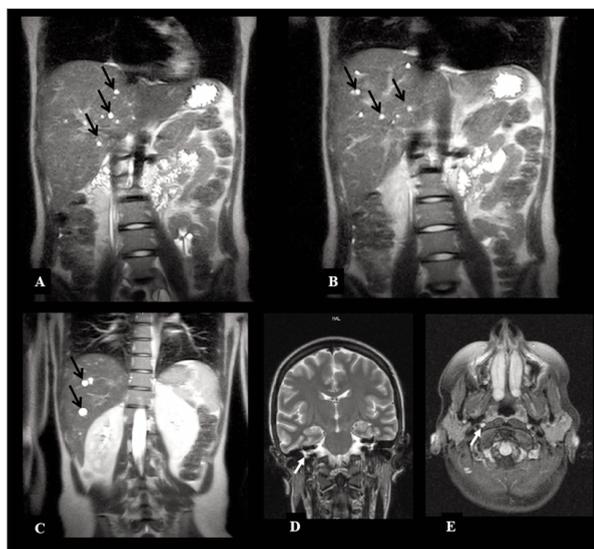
A-C: Black arrows highlight multiple nodules appearing hyperintense in T2W1 MRI sequence suggesting hepatic abscesses; D-E: Brain MRI reveals enhancement of the VIII cranial pairs (white arrows), as well enhancement of the membranous labyrinths of the inner ear, bilaterally in T2, aspects suggestive of neuritis and bilateral labyrinthitis.
